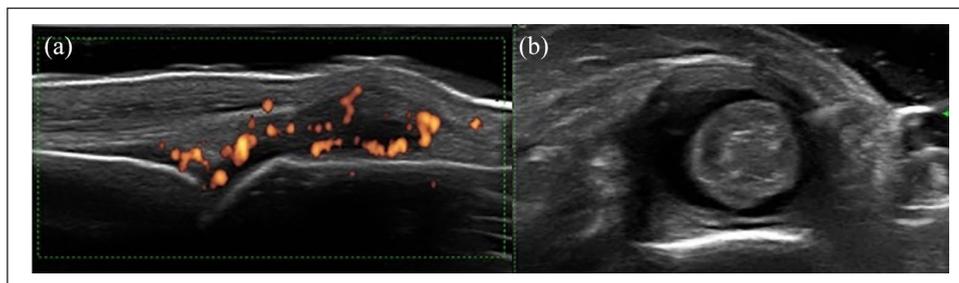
Inflammatory joint and tendon disease in SSc as assessed by MSK US. (a) Synovitis: metacarpophalangeal joint in dorsal scan showing synovitis with synovial proliferation and intra-articular power Doppler signal. (b) Tenosynovitis: transverse scan of the tibialis tendon which demonstrates moderate tenosynovitis.
